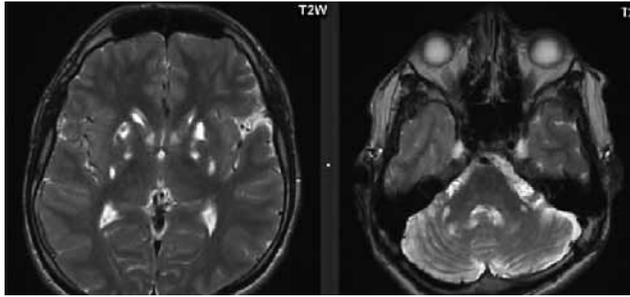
Brain MRI of the first patient with Leigh syndrome. Axial T2 weighted images. Bilateral, symmetric abnormal hyperintensity in the putamina, caudate and globi pallidi in the first image; bilateral hyperintensity in the cerebellar dentate nuclei, middle cerebellar peduncle and cerebellum atrophy in the second image.
